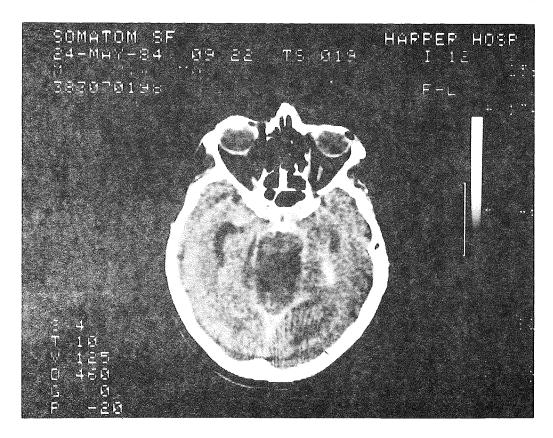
CT scan obtained on same day as VEP recording showing extensive lucency involving brainstem up to midbrain level.
